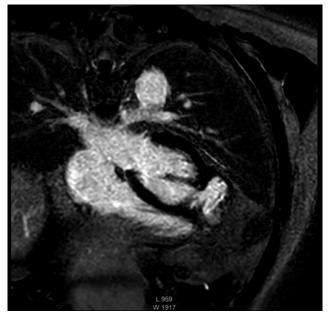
Cardiovascular magnetic resonance imaging, LGE sequence 4-chamber display, demonstrates the complex LV apical aneurysm comprising 2 interconnected, focal, thin-walled outpouching myocardial segments with a thin subendocardial layer of LGE lining the aneurysm walls.
